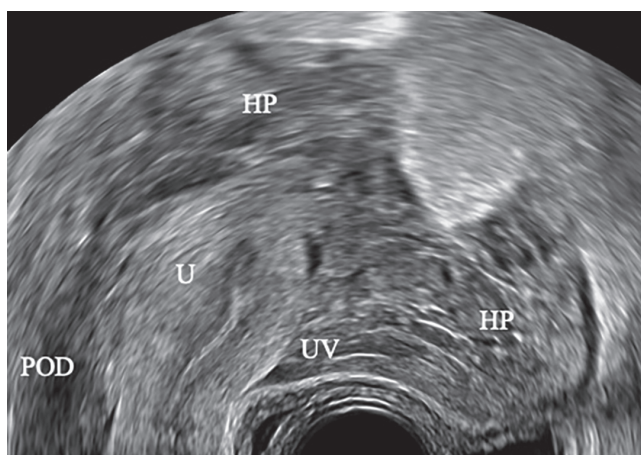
Transvaginal ultrasound image in longitudinal view of uterus (U), showing echogenic fluid and blood clots in pouch of Douglas (POD) and uterovesical fold (UV), indicating severe hemoperitoneum (HP).
